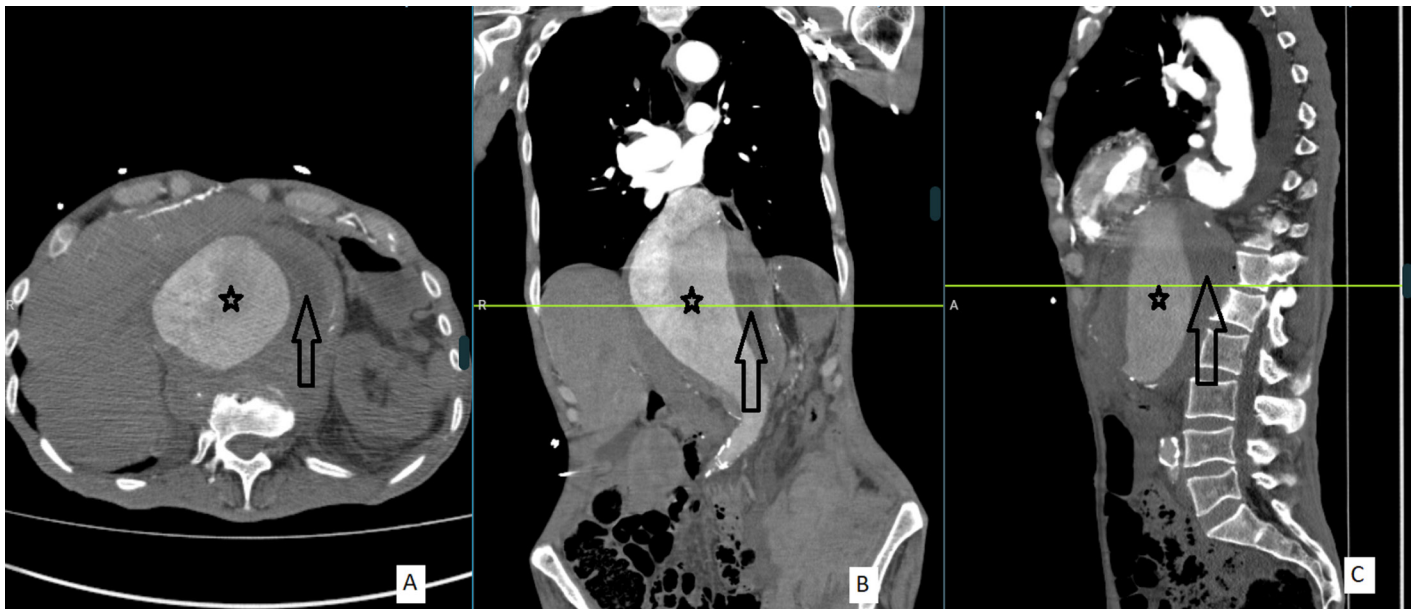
Computed tomography images of an abdominal aortic aneurysm diagnosed as resting in the emergency department. This patient was unsuitable for endovascular intervention and was treated with open surgery. “*” indicates the true lumen, while “→” indicates the thrombosis of aneurysmatic wall.
